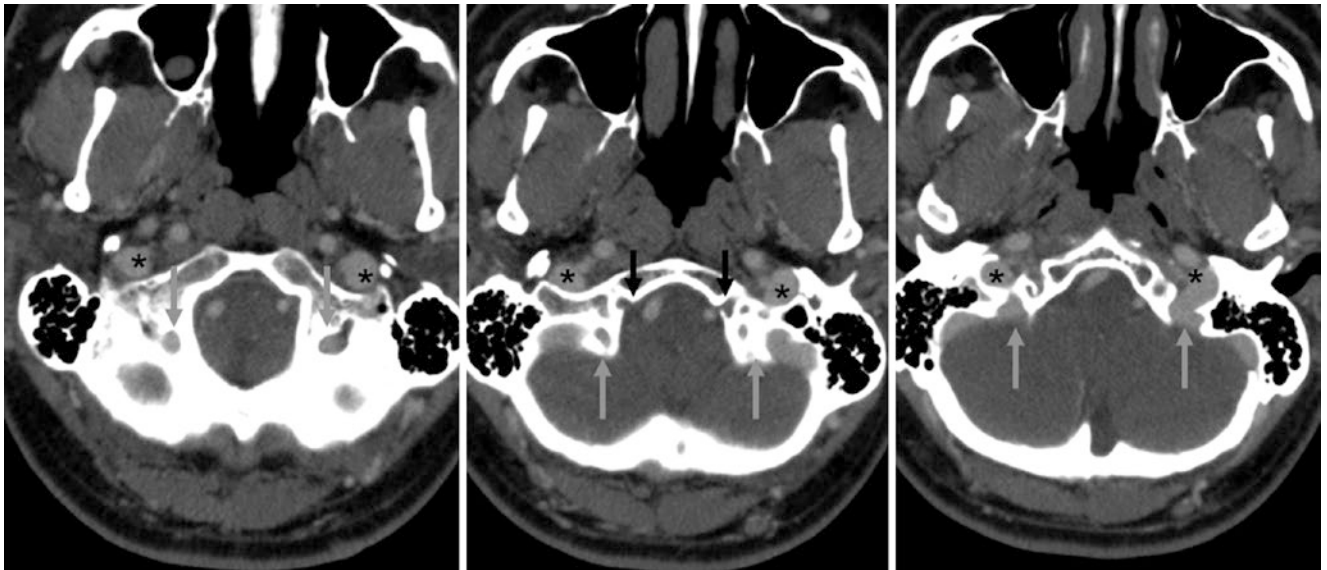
A 45 year old: on postcontrast CT, the bilateral condylar veins (*grey arrows*) drain into the jugular foramina/veins (*asterisks*), which faintly opacify with contrast. Note the hypoglossal canals (*black arrows*)
